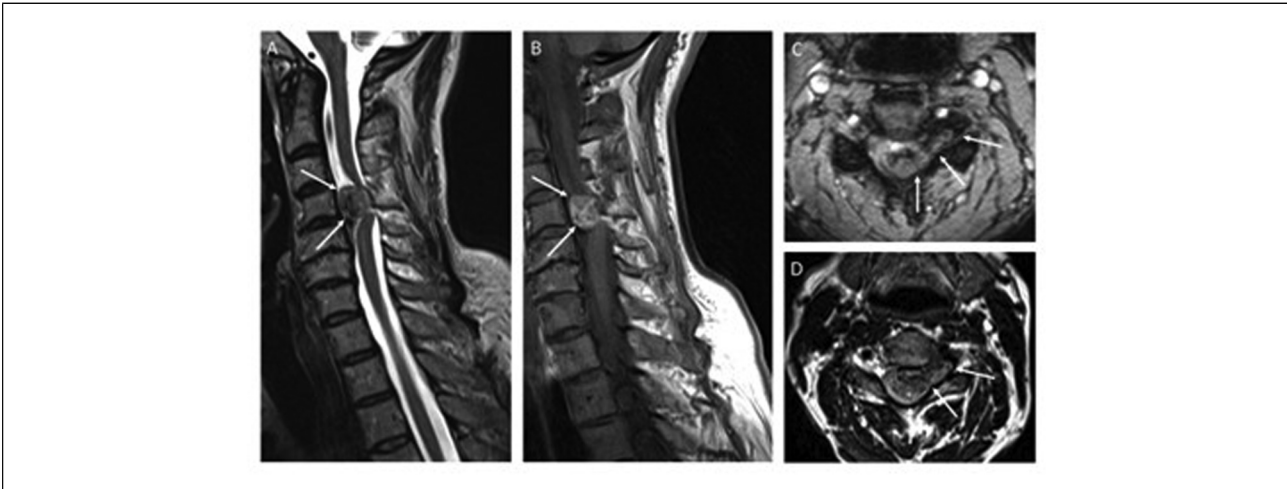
Magnetic resonance imaging. Sagittal T2- (A) and T1-weighted (B) images show an extramedullary intradural neoplastic lesion compressing the cervical spinal cord. The lesion is mainly hypointense on T2 and hyperintense on T1 due to melanin pigment. Axial T2*- (C) and T2-weighted sequences confirm these findings and demonstrate foraminal extension.
